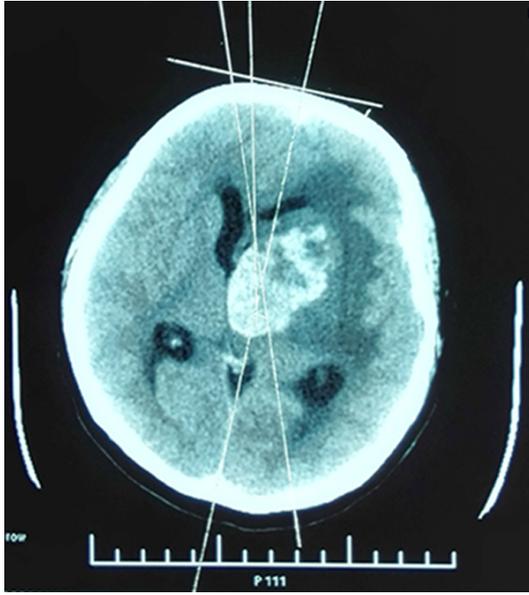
CT image prior to surgery.
